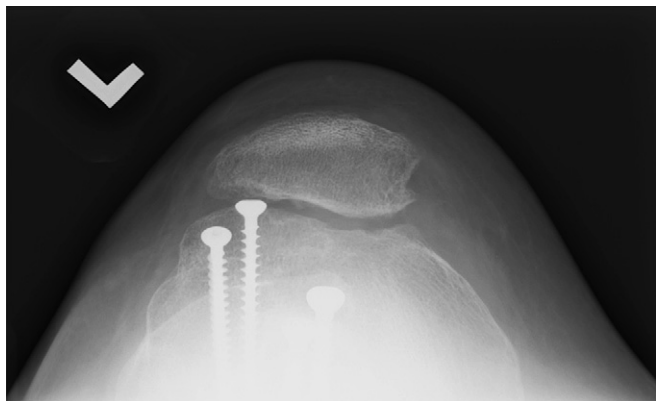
Postoperative merchant view at 1-year follow-up shows healed trochlear osteotomy and reduced patella. Radiographic parameters, including sulcus angle, congruence angle, and axial linear patellar displacement, all improved much.
